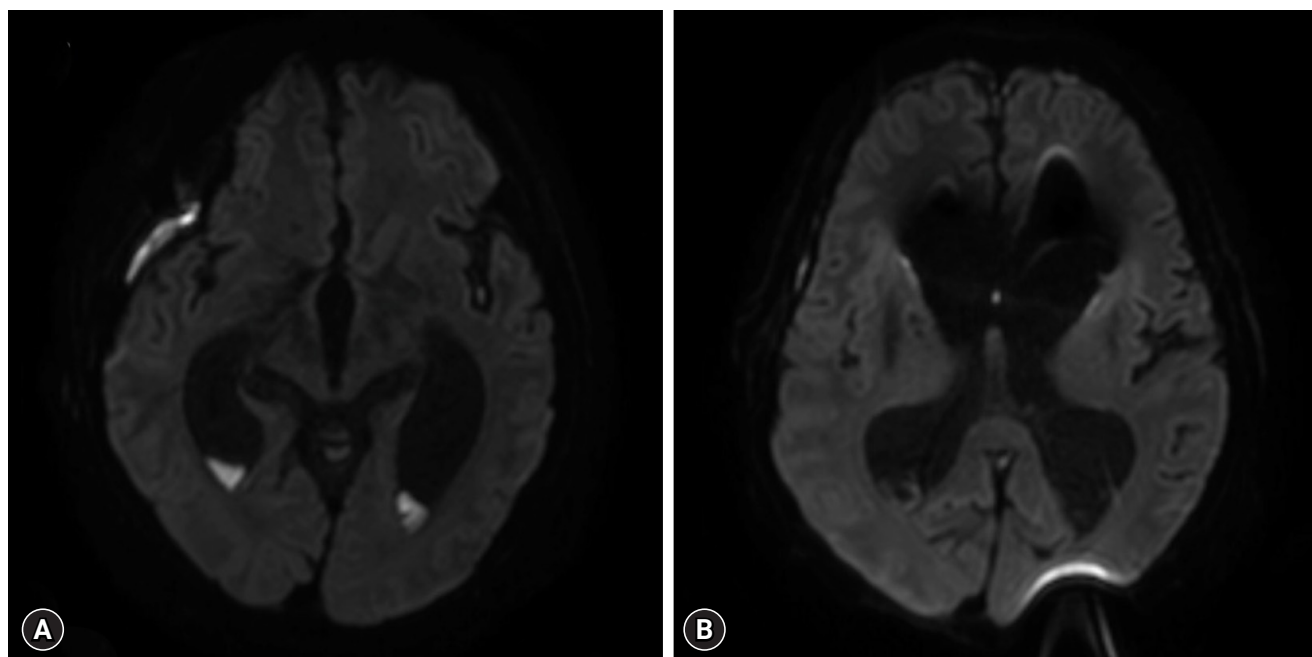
Comparison of magnetic resonance imaging (MRI) diffusion sequences before and after endoscopic lavage. (A) Preoperative MRI diffusion images show prominent high signal intensity, suggesting infectious material. (B) Postoperative MRI diffusion images show a reduction in high signal intensity, indicating improvement of infection.
